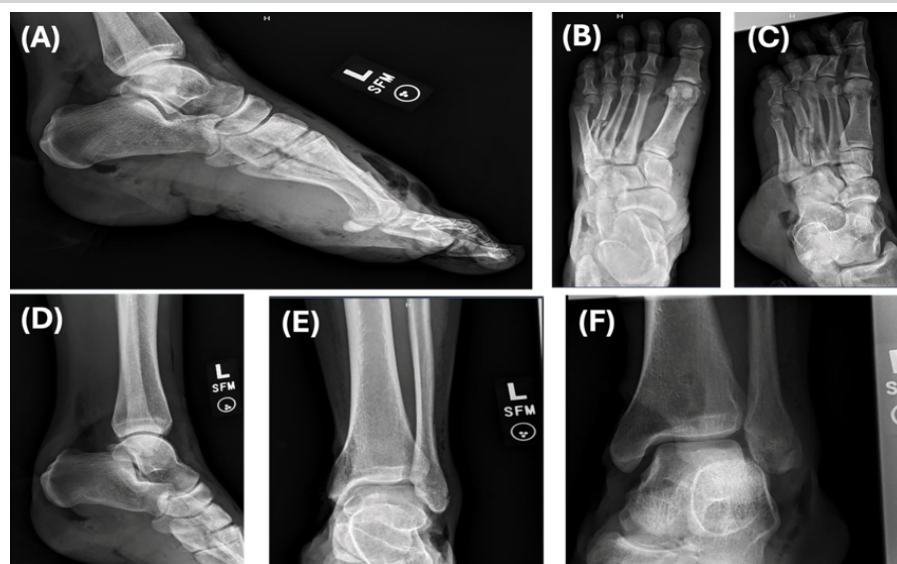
(a-f) Initial radiographs of the left ankle and foot following the accident.
